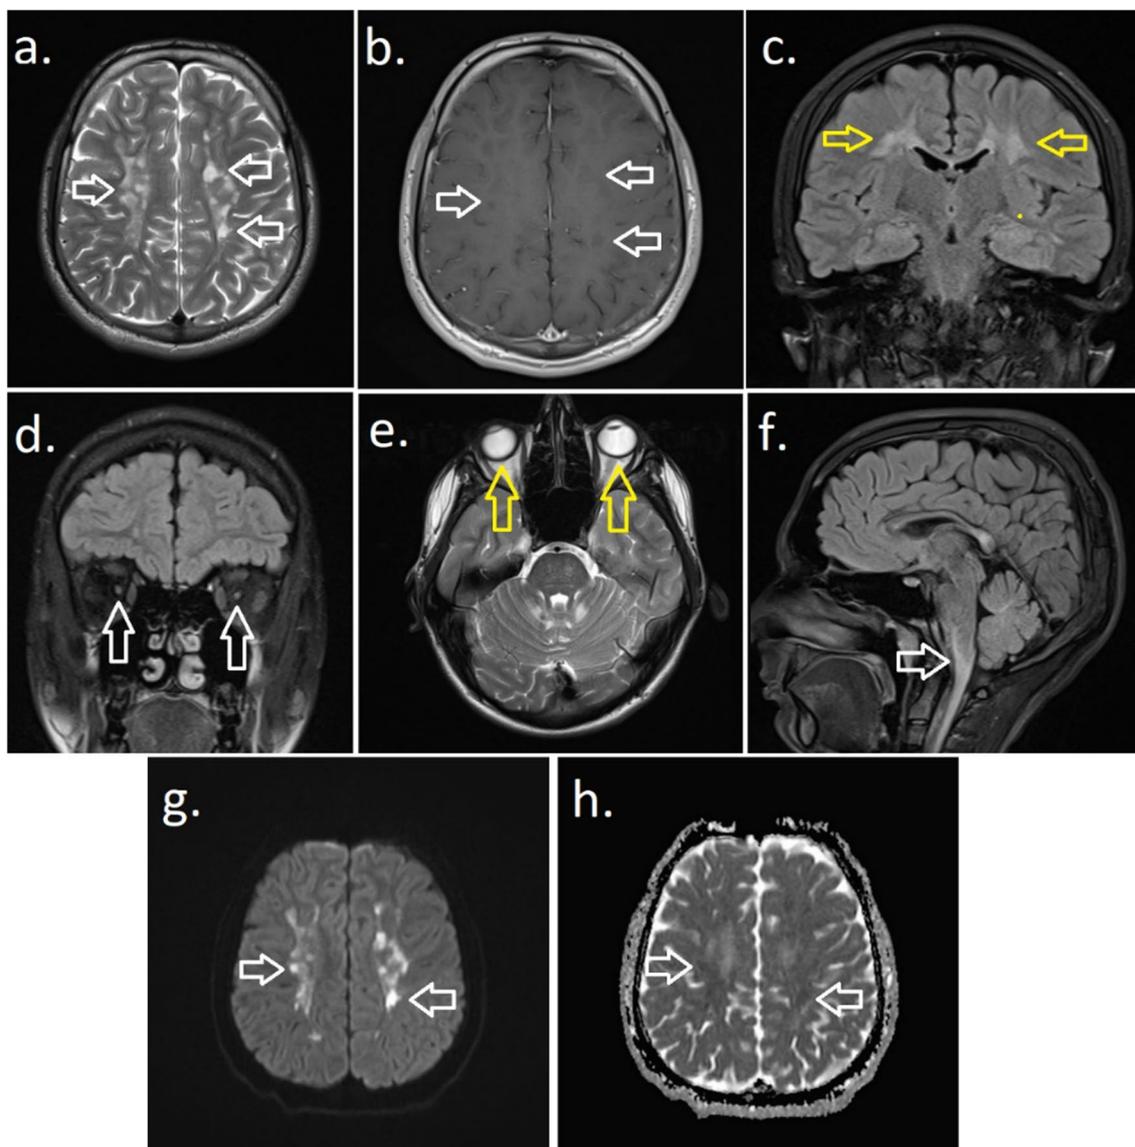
a T2 axial MR image: hyperintensity at periventricular white matter (white arrows), b contrast-enhanced T1 axial MR image: no contrast enhancement is seen at the same white matter lesions (white arrows), c coronal FLAIR (Fluid-Attenuated Inversion Recovery) MR image: same lesions on periventricular white matter (yellow arrows), d bilateral atrophic optic nerves (white arrows), e bilateral micro-ophthalmia (yellow arrows), f sagittal FLAIR image: atrophy and hyper-intensity on brainstem (white arrow), g diffusion restriction on diffusion-weighted image and h on ADC (apparent diffusion coefficient) map (arrows)
